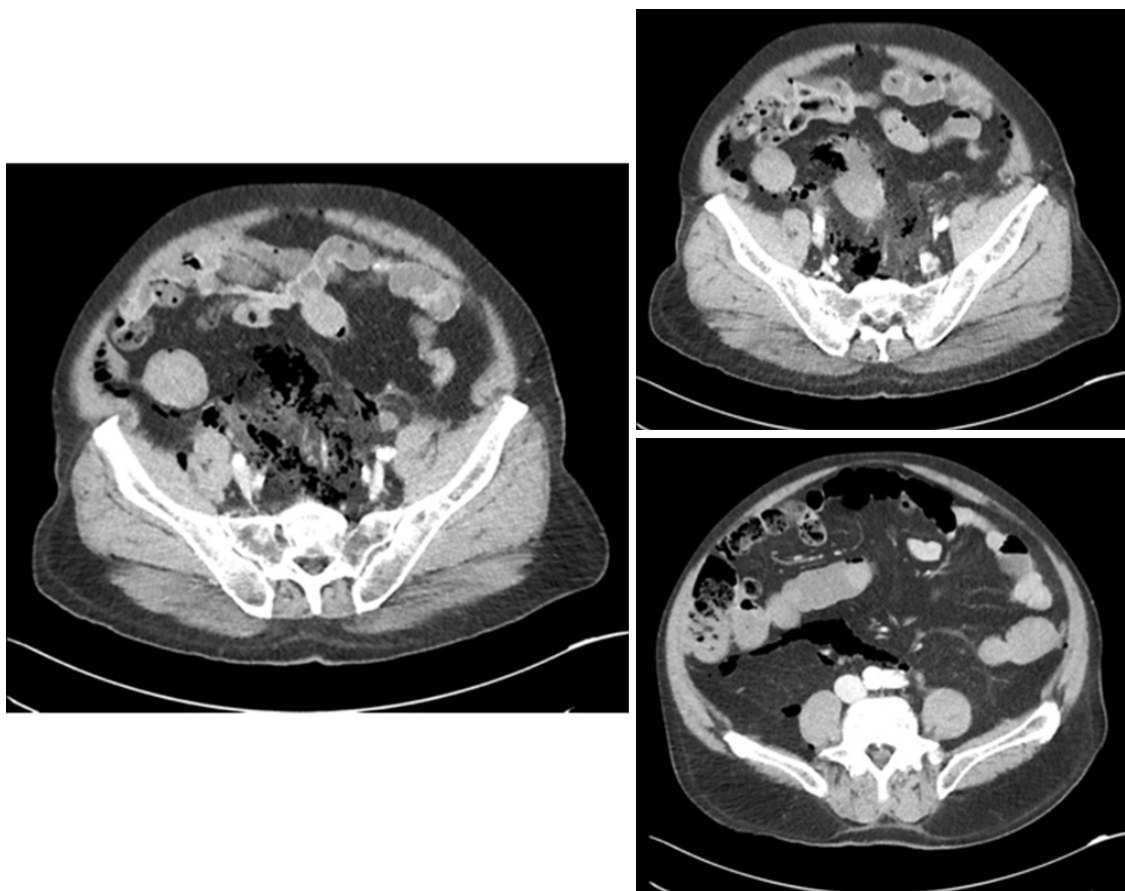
Abdominal computed tomography scan with pneumoretroperitoneum, without intra-abdominal free fluid or collections
